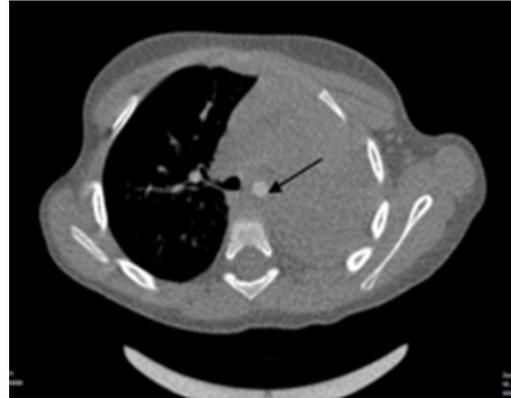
CT scan of the chest (Axial view) showing the complete collapse in the left lung and foreign body mass in the Lt. main bronchus (arrow)
